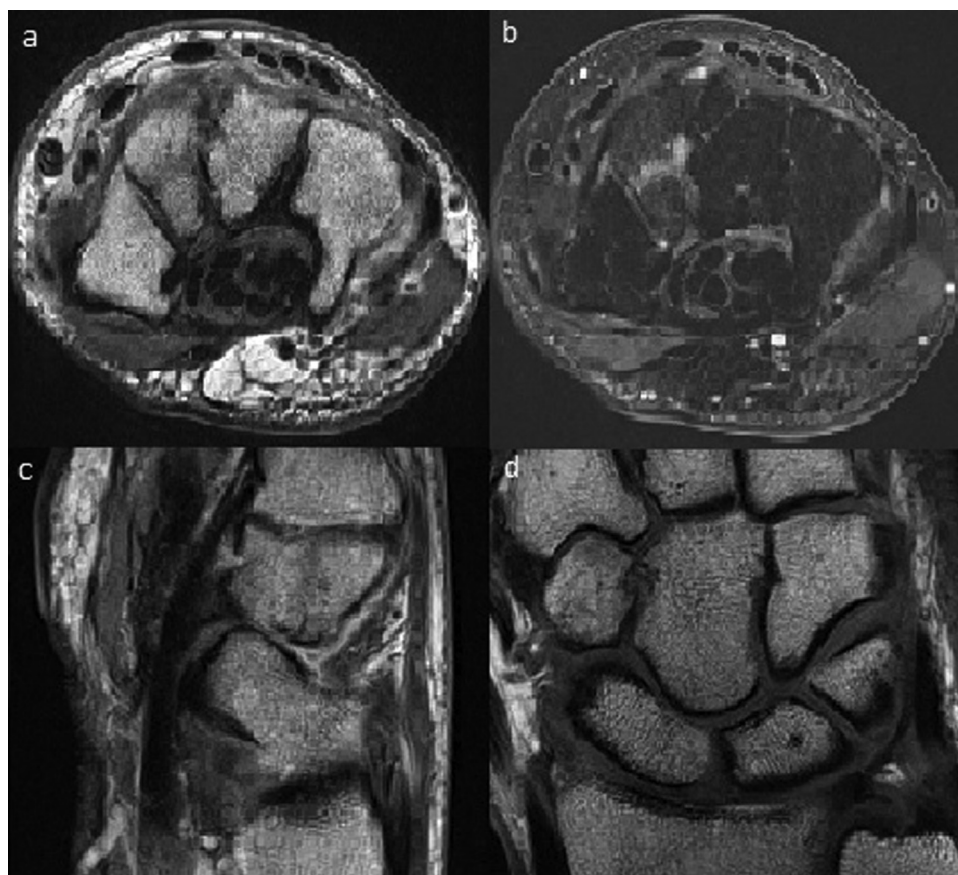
Axial proton density image (a) demonstrates a coronally-oriented band of low signal with corresponding edema on both axial T2, fat-saturated (b) and sagittal T2, nonfat-saturated images (c), similar to [Figure 2](#). The fracture is not visible on coronal T1-weighted images and the remainder of the exam shows no evidence of fracture or additional traumatic injury (d).
